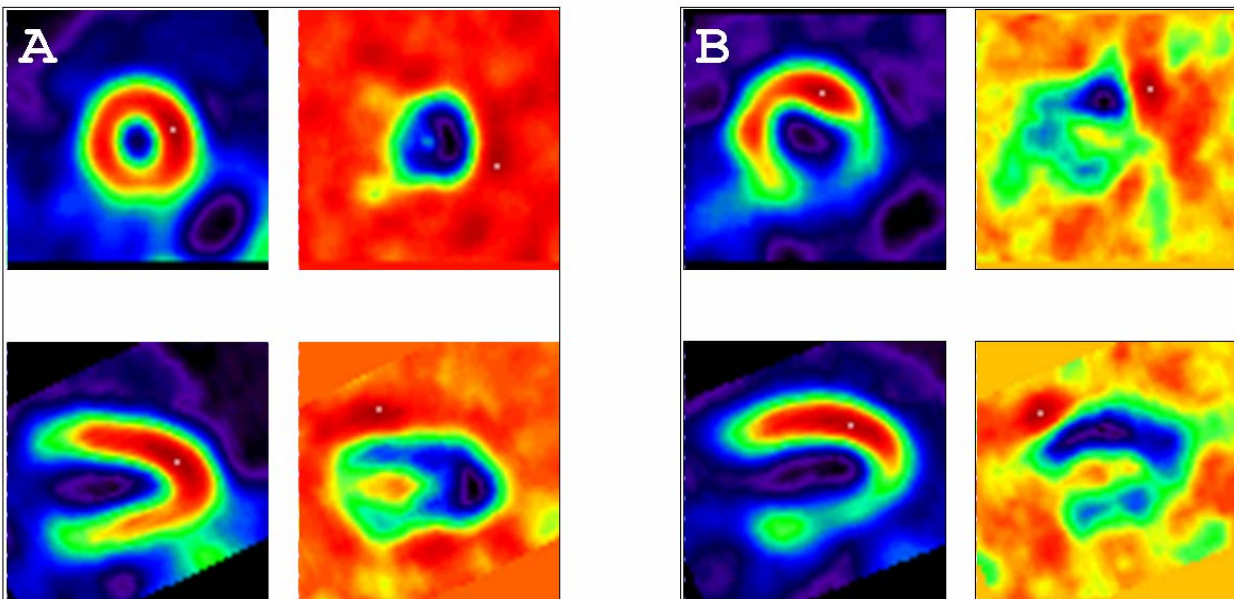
KL0 and KL1 images from gSPECT in a healthy man (A) and in a patient after myocardial infraction (B) – short axis (top line) and horizontal long axis (bottom line).
